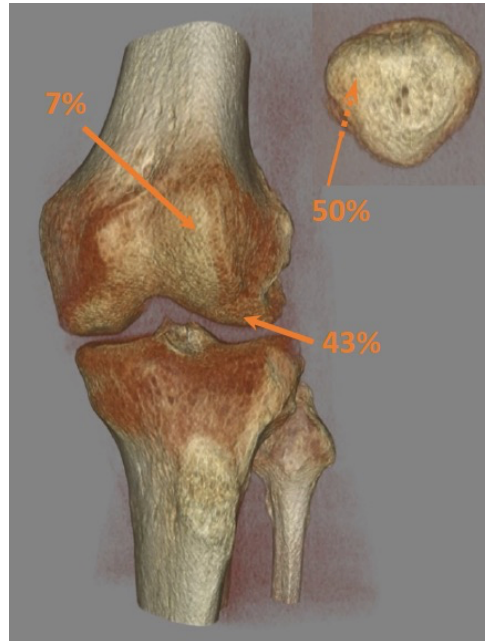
Distribution of 113 concomitant injuries to articular surfaces. 3D-CT of left knee. Pure chondral lesions (n=69), osteochondral fractures (n=34), and impaction fractures (n=10) in 75 (43%) knees with concomitant articular surface injuries.
